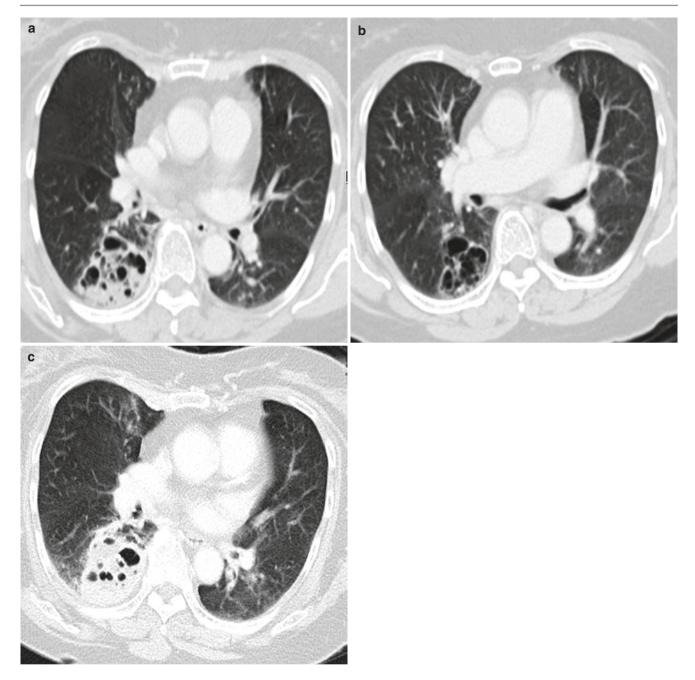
A 41-year-old woman with CCAM presenting with recurrent pulmonary infection. (a) Axial CT image on initial presentation shows a multicystic mass with the eccentric solid component. (b) Follow-up CT scan
